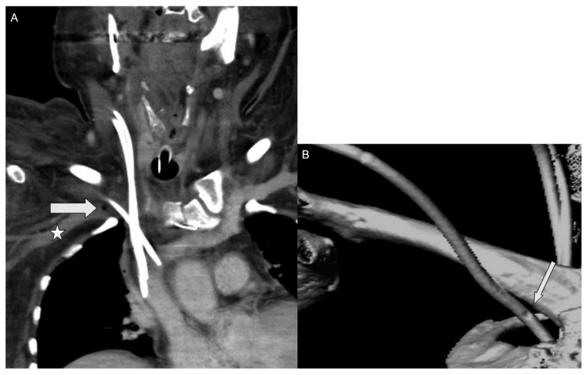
A: Curved multi-planar average reconstruction (1.8 mm slice thickness, WL 210 WW 610) of a multi-slice computed tomography data set (Aquillion 64, Toshiba Medical Systems, Tustin, California), 2 min after bolus injection of 100 mL iobitridol). The right subclavian vein is marked with an asterisk. At the insertion point of the central venous line into the right subclavian vein an air bubble (solid arrow) and lack of a contrast filled vessel identifies the extravasation injury. B: Shaded surface reconstruction of the insertion point, which shows the proximal lumen of the catheter placed anteriorly in front of the right clavicle outside the venous vessel (solid arrow).
